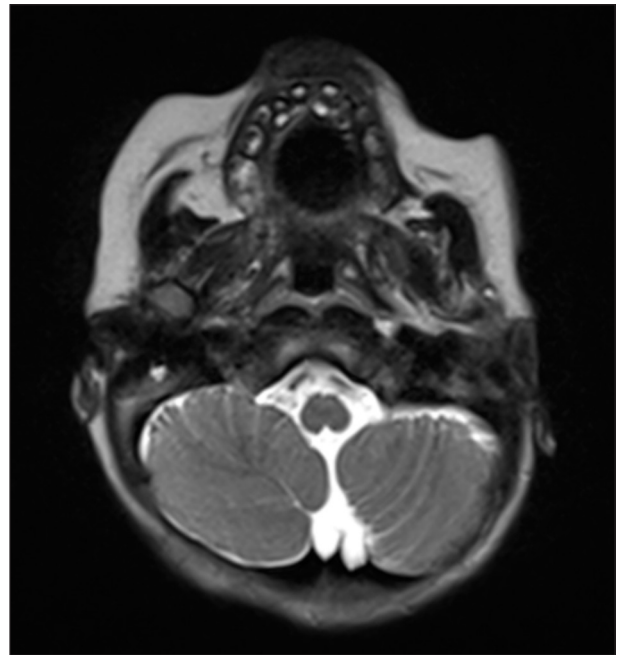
Coronal T2-weighted image shows absence of cerebellar vermis.
